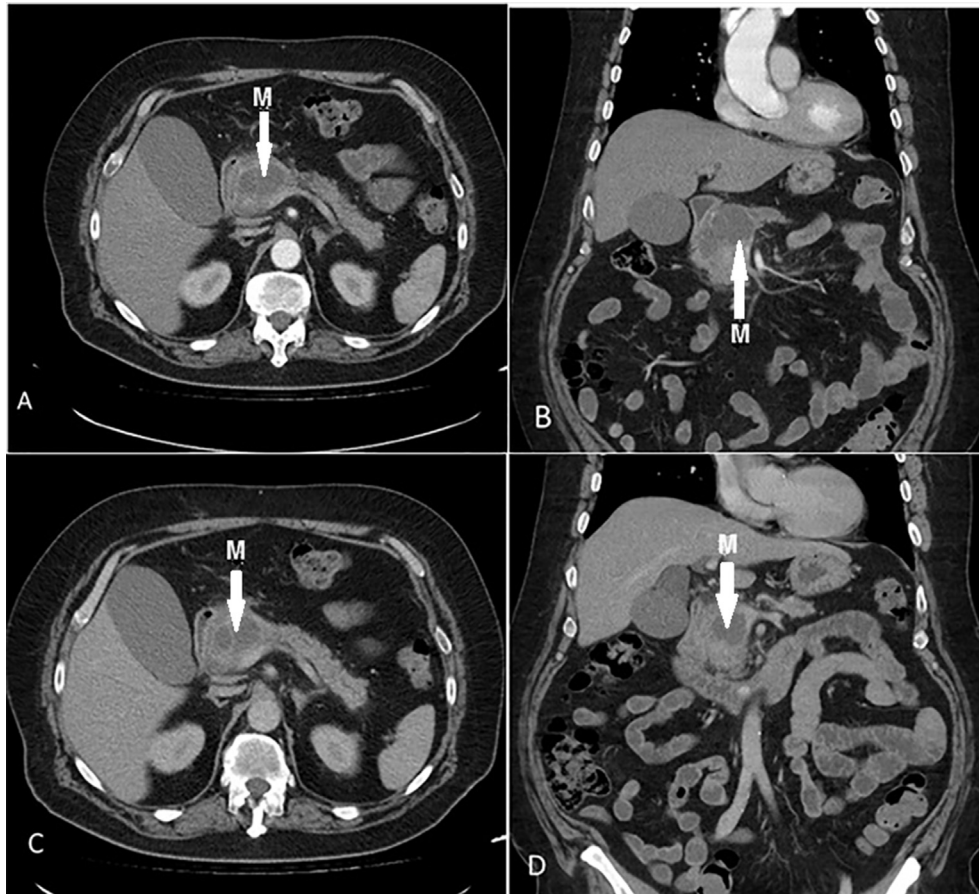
Abdominal contrast-enhanced CT scan showing the solid and cystic mass in the head of the pancreas. Axial (A) and coronal (B) images in the arterial phase. Axial (C) and coronal (D) images in the portal phase. The lesion invaded the portal vein.
